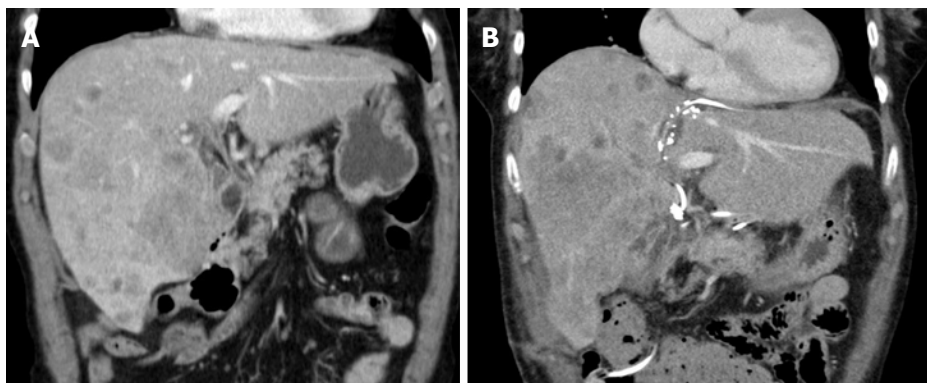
Computed tomography scan before associating liver partition and portal vein ligation for staged hepatectomy in a patient with intrahepatic cholangiocarcinoma and on day 10 after liver partition. A: The future liver remnant consisted of segment 2 and 3 with volume of 347 mL (23% of the standardized total liver volume); B: Showing the hypertrophy of the segment 2 and 3 with volume of 610 mL (41% of the standardized total liver volume).
